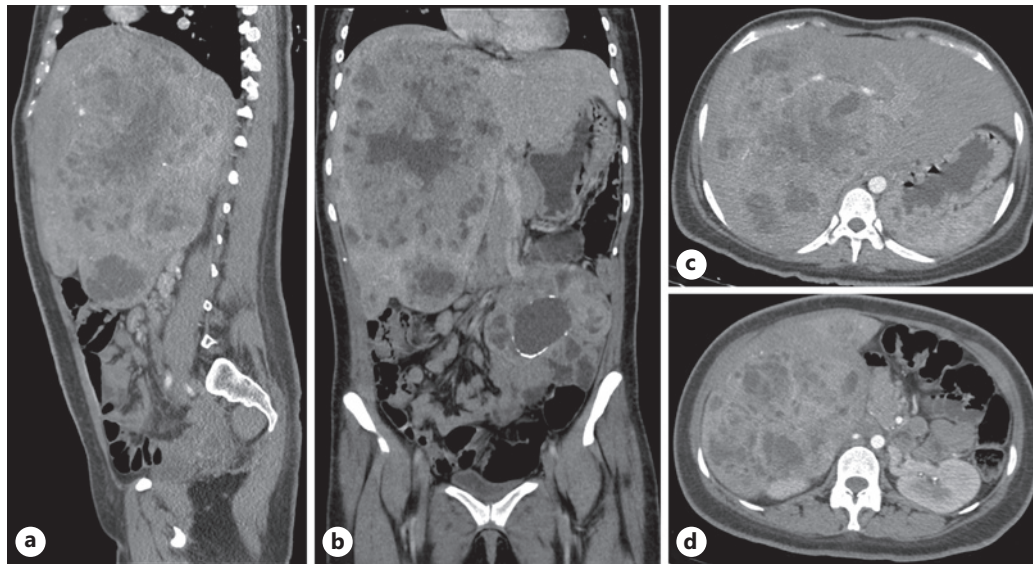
Chest-abdomen-pelvis computed tomography (CT) scan. Coronal (a, b) and axial (c, d) CT projections showing a voluminous abdominal mass (mesenteric tumor) of 126 × 96 mm, and liver tumor of 213 mm × 155 mm in both lobes with significant contrast enhancement due to hypervascularization (a–d).
